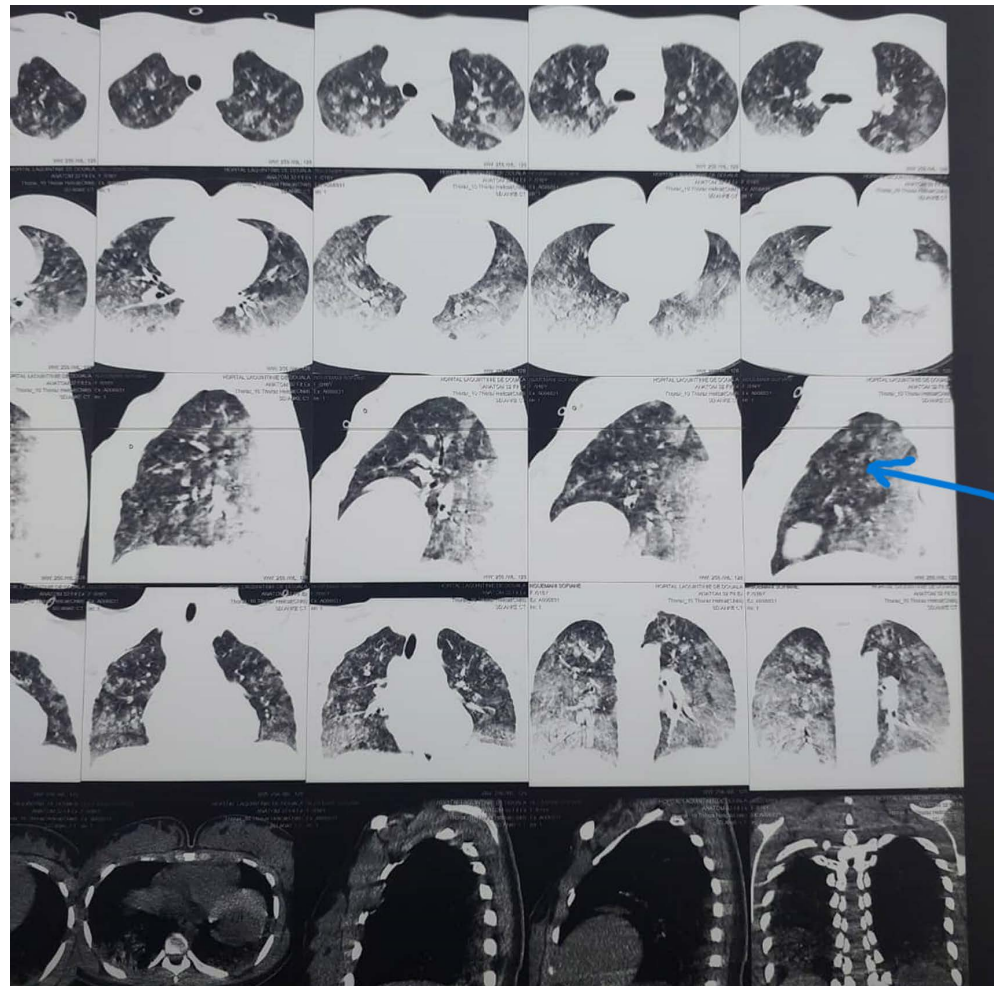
The “ground glass” aspect of the lungs on the chest CT scan.
